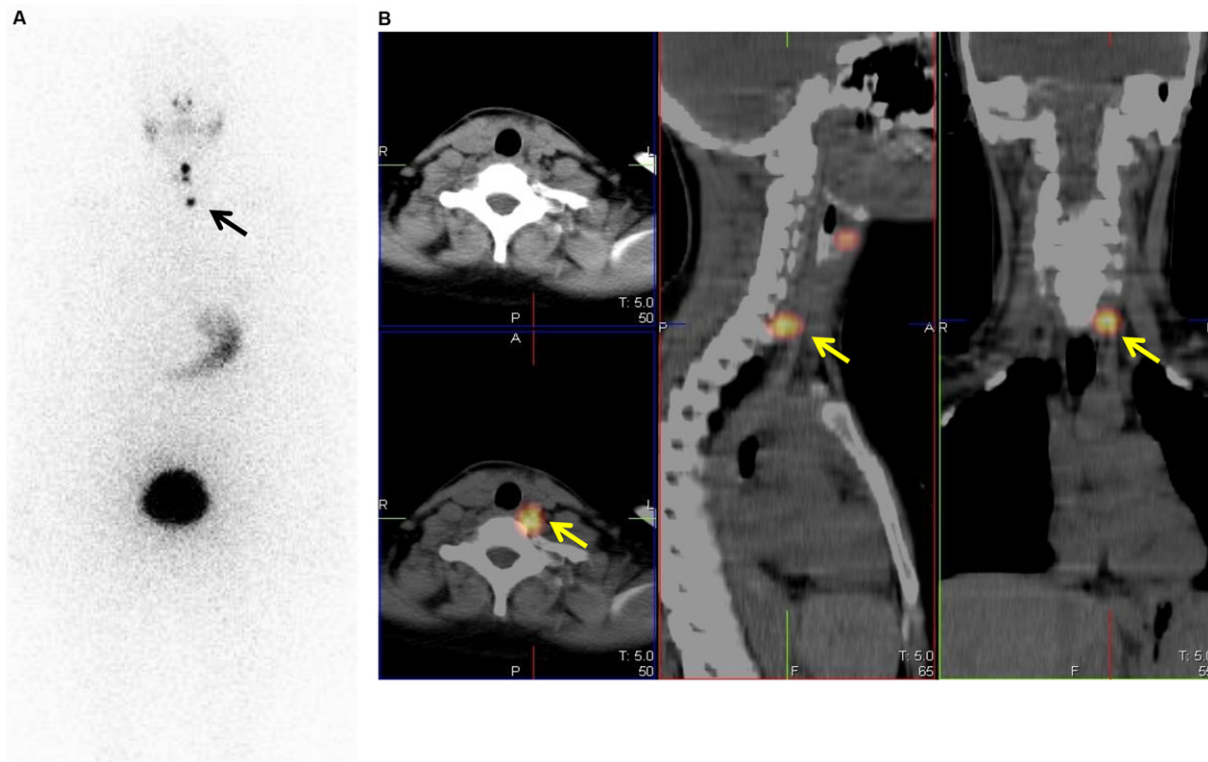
Post-surgery ^{123}I WBS (A, anterior view) and SPECT/CT (B) in a 34 years old female affected by papillary thyroid carcinoma (p1b Nx) showing residual thyroglossal duct and a radioiodine-avid lymph node metastases (arrow).
